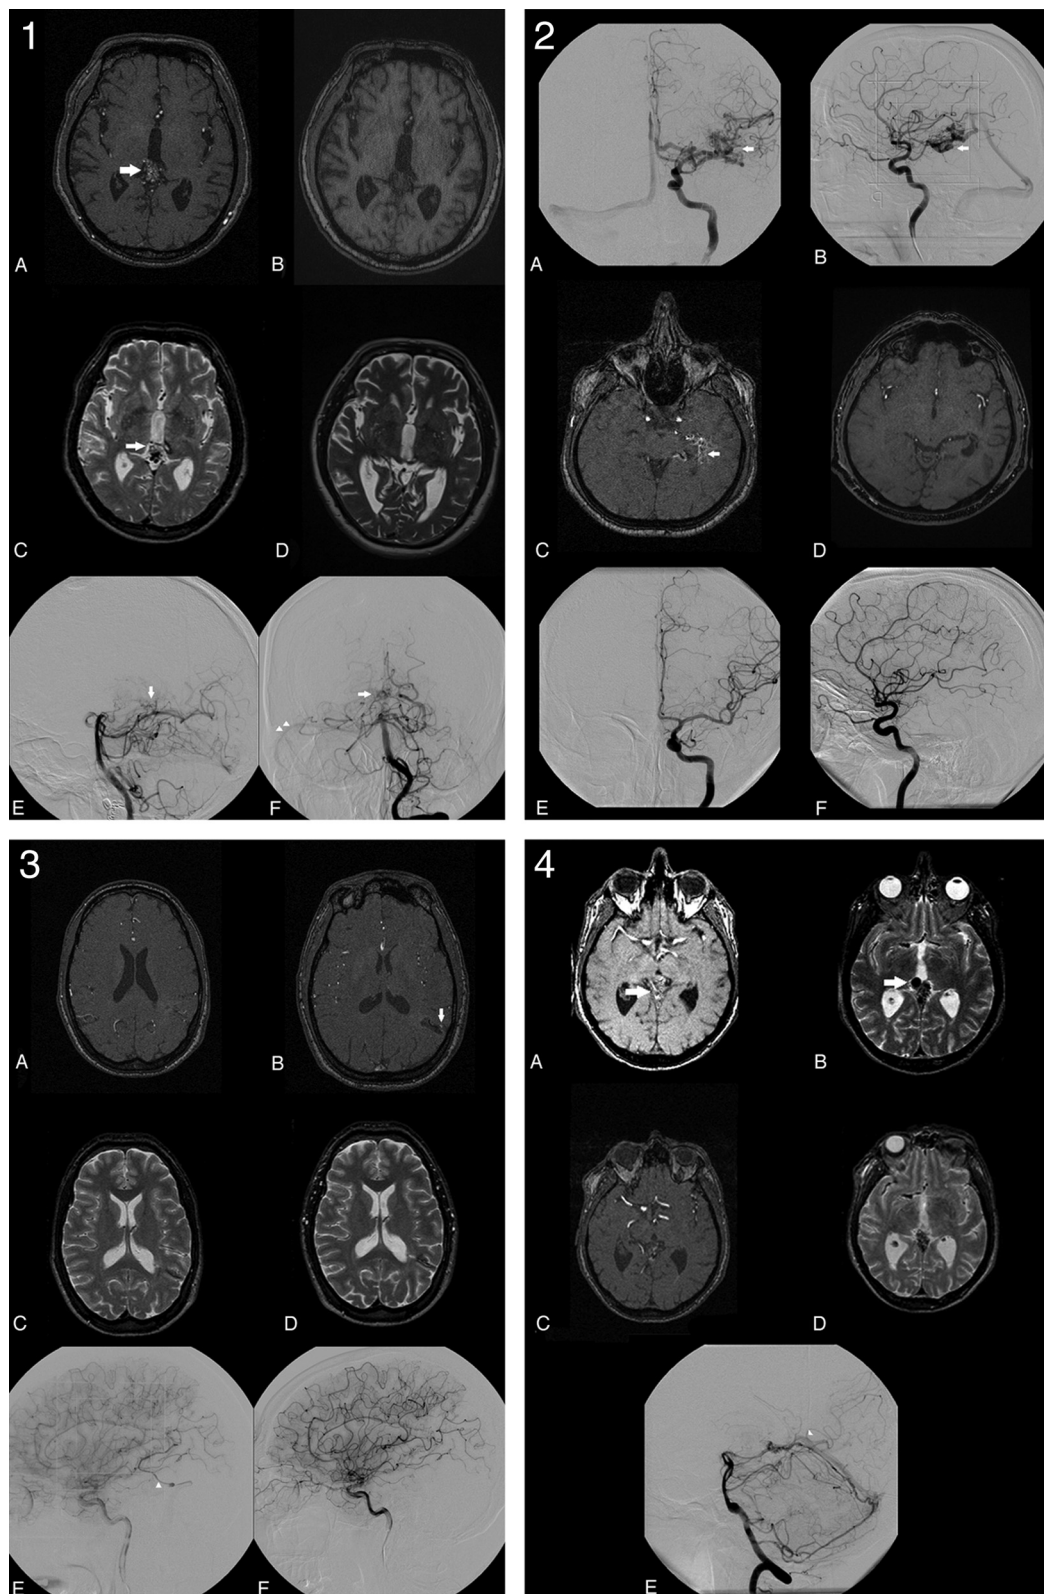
1, Overestimation of nidus obliteration: a 0.90-mL tectal bAVM, which is clearly visible on MR imaging₁ (A and C white arrows). A–F, Both observers determined this bAVM to be obliterated on MR imaging₂ (B and D) almost 3 years later. However DSA₂, performed 6 weeks after MR imaging₂, still demonstrates a small nidus (E and F, white arrows) with early venous drainage toward the lateral sinus (F, white arrowheads). 2, Successful determination of nidus obliteration in the case of a 3.68-mL-deep temporal bAVM (straight white arrow, A–C). On the basis of MR imaging₂, both observers agreed that the nidus was obliterated 25 months after radiosurgery (D). Obliteration was angiographically confirmed 6 weeks later (E and F). 3, Underestimation of nidus obliteration: a small 0.17-mL central bAVM that was previously partially treated by endovascular embolization (A, C, and E). Because of hyperintensity on MR imaging₂ (B, white vertical arrow), both observers judged this bAVM to be patent 1 year after radiosurgery (B and D). However DSA₂ (F), performed 2 months after MR imaging₂, demonstrates absence of the previously present early venous drainage (E, white arrowhead). 4, Successful determination of a remaining nidus in case of a patent 2.32-mL tectal bAVM (white horizontal arrow, A and B). On the basis of MR imaging₂, both observers agreed that the nidus was patent 4 years after radiosurgery (C and D). The presence of a remnant nidus was angiographically confirmed 6 weeks later, when early venous drainage toward the straight sinus was observed (white arrowhead, E).
